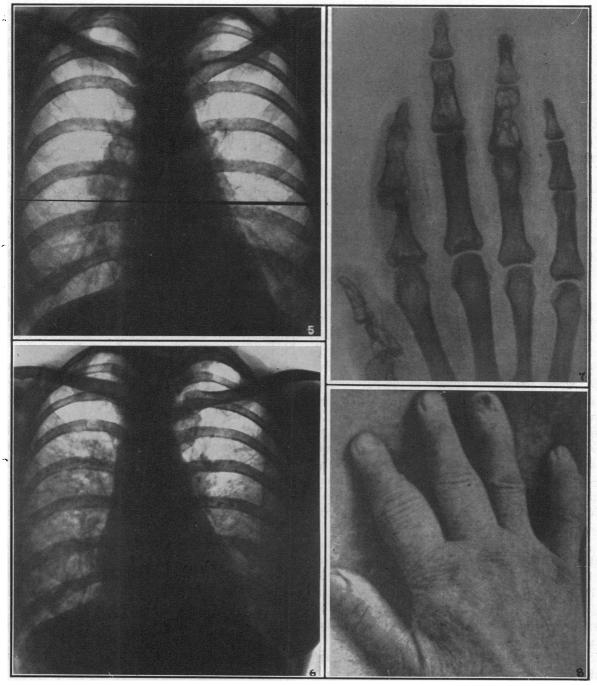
Roentgenograms of chest to show right hilar lymphadenopathy. Fig. 6.—Same case as in Fig. 5, five years later. Note that hilar enlargement is not now prominent, and that "marbling" of the middle and lower zones has occurred, the apices remaining relatively free. Fig. 7.—Roentgenogram of hand, showing multiple lacunæ in phalanges. This is an advanced case, and pathological fracture of the index finger has occurred (after Nielsen). (Courtesy of Masson et Cie., Paris). Fig. 8.—Hand showing distortion of fingers, closely resembling appearance of rheumatoid arthritis. Note erosion of one nail-bed (after Whittle). (Courtesy of H. K. Lewis & Co., London).
